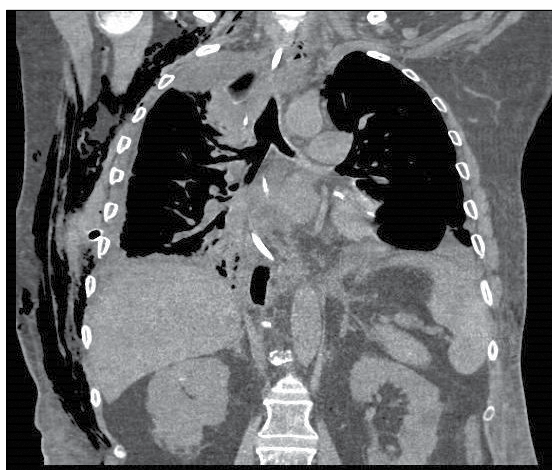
Sagittal slice from a CT scan of the chest. It was not possible to clearly identify the vegetative lesion in the right main bronchus and lobar bronchi (including the right upper lobar bronchus) with this imaging modality.
